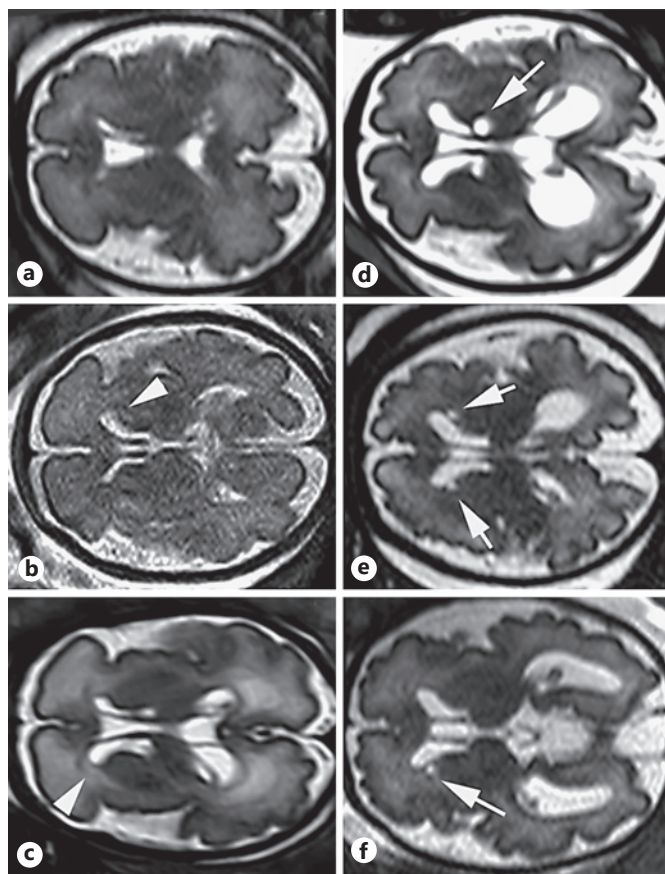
Axial T2-weighted MR images at the level of the anterior complex. a Normal fetus at 28 weeks' gestation. b Peri-intraventricular hemorrhage (arrowhead) at 32 weeks' gestation. c Periventricular white matter hyperintensities (arrowhead) reflecting edema, gliosis, or demyelination in a fetus at 32 weeks' gestation affected by congenital cytomegalovirus leukoencephalopathy. d Isolated germinal matrix cyst (arrow) at 32 weeks. The long-term outcome demonstrated sensorineural hearing loss. e Image of bilateral germinal matrix cysts (arrows) obtained at 32 weeks' gestation in a fetus affected by pontocerebellar hypoplasia. f Connatal cyst (arrow) associated with mega cisterna magna in a fetus at 32 weeks' gestation. The final diagnosis was glutaric acidemia type 2.
